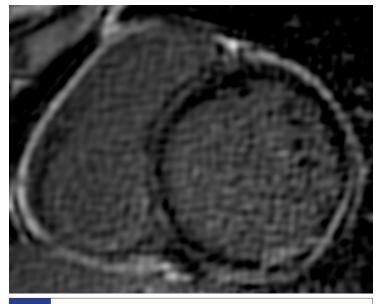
Cardiac MRI (2011) 2D Inversion Recovery Turbo Field Echo (IRTFE) image at the basis showing circumferential enhancement of the left ventricle and thick inferior subepicardial delayed enhancement (DE).
